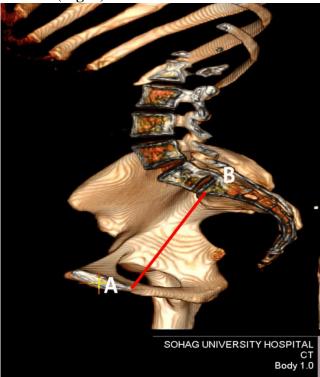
An Image of pelvic 3D volume rendered reconstruction of CT scan; obstetric conjugate diameter extending between symphysis publis lower border (A) and sacral promontory tip (B)
